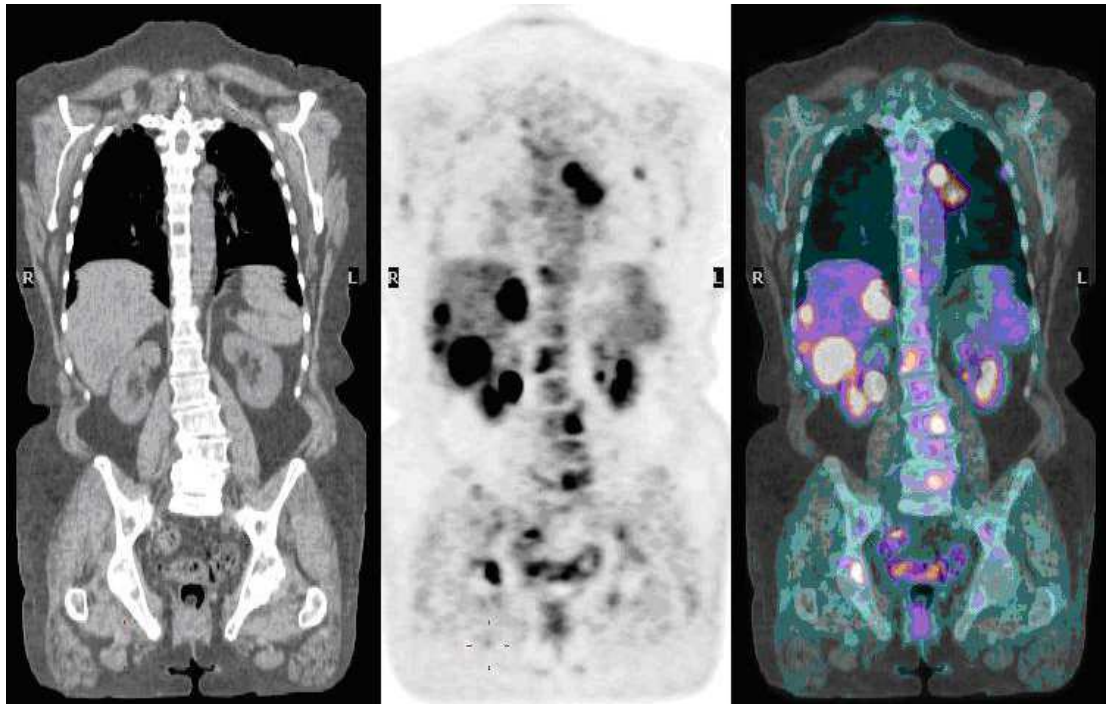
Visualisation of a slice of a whole body PET-CT scan. Left: CT. Middle: PET, with regions of high metabolic activity shown in black. Right: fused PET-CT image, with areas of high metabolic activity shown in white. © Myo Han / Wikimedia Commons / used under the terms of the CC-BY-3.0 license.
